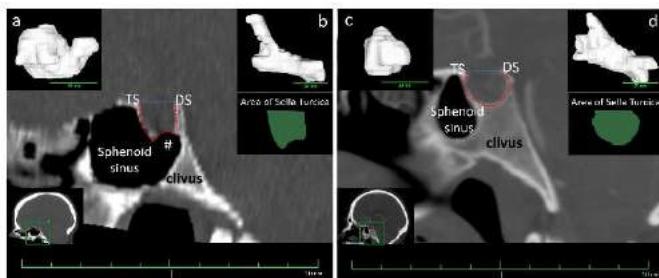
Side-by-side comparison of CT sagittal view of the sphenoid sinus in a CMI subject (left) and an age- and BMI-matched control (right): Lateral view of (a) sphenoid sinus and (b) clivus for the CMI subject. Lateral view of (c) sphenoid sinus and (d) clivus for the control. The red dashed line shows the trace line used to determine area of the sella turcica: TS, tuberculum sella; DS, dorsum sella; the area labeled as # in the image at the left represents invagination of the clivus in the CMI subject.
